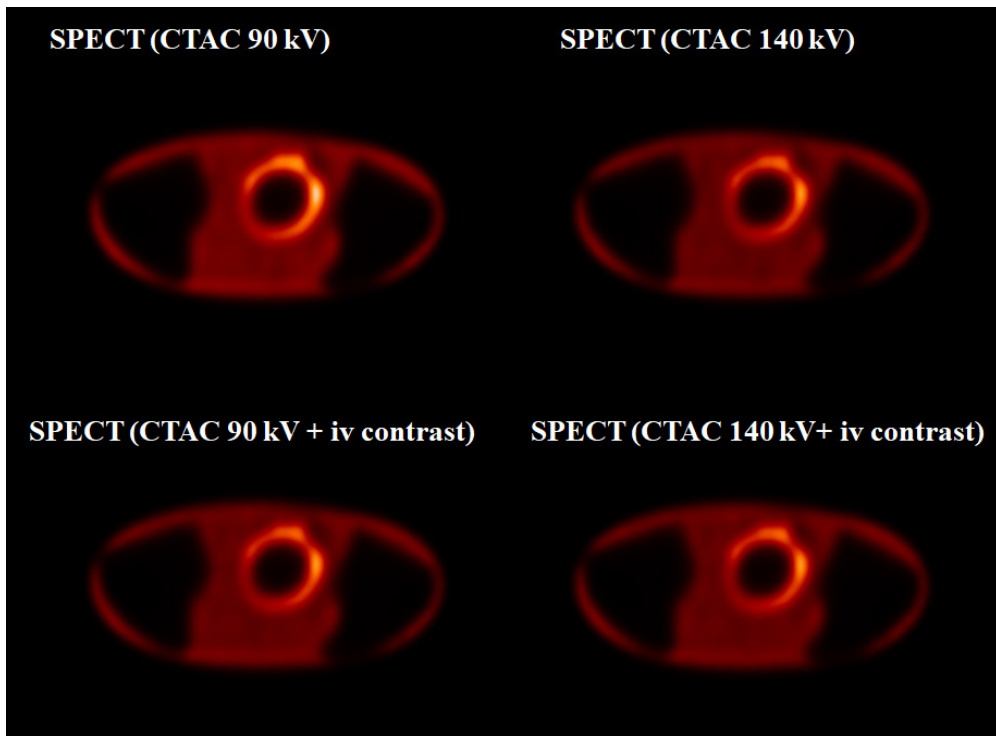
Reconstructed SPECT images based on attenuation maps from two different CT kV values, with and without contrast. It is difficult to detect differences by pure visual inspection.
